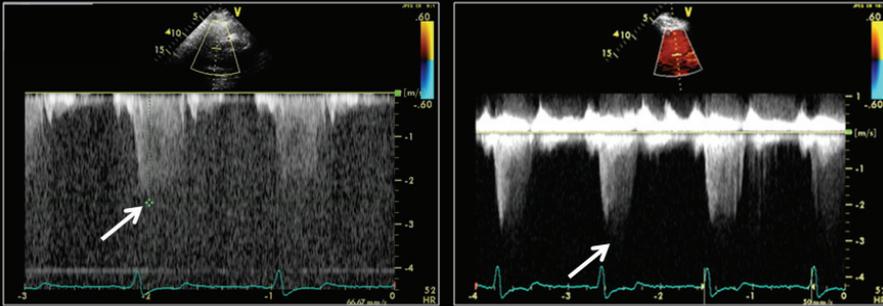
Continuous wave spectral Doppler display of tricuspid regurgitation (TR). Left. Unenhanced systolic image with weak Doppler display demonstrating a maximal TR velocity of 2.5M/s or 25mmHg gradient (arrow). Right. Contrast enhanced image with increased signal to noise ratio able to confirm the maximal systolic velocity approaching 3.0M/s or 36mmHg (arrow)
